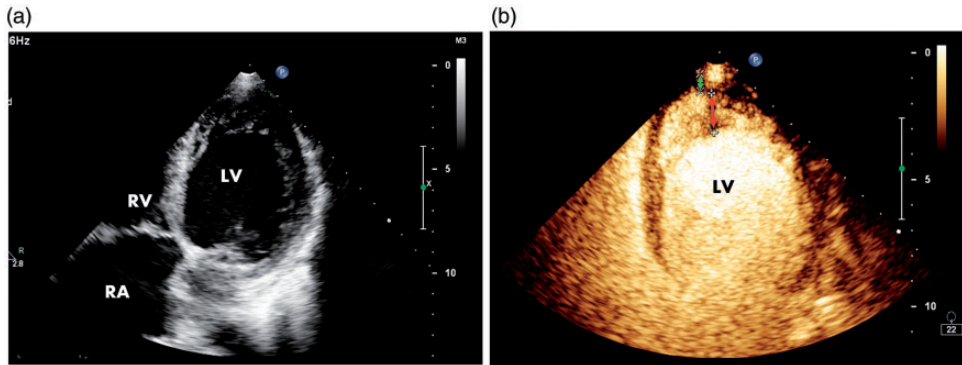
Compared with (a) cardiac ultrasound, (b) contrast echocardiography (left ventricular opacification) reveals prominent trabeculations in the lateral-apical wall of the left ventricle and intertrabecular recesses filled with slow blood flow that is in continuity with the left ventricular cavity. A thin compacted outer band (green arrow) and a thicker, noncompacted inner layer (red arrow) are visualized. RA, right atrium; RV, right ventricle; LV, left ventricle.
